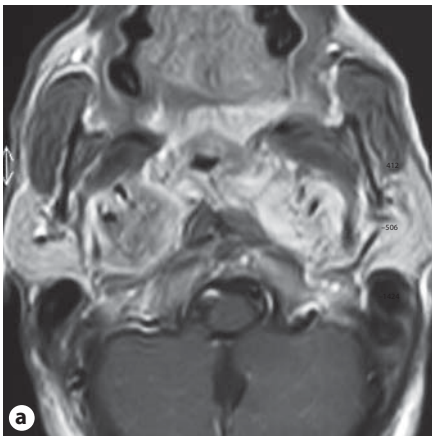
Case No. 9. a Axial T₁-weighted MR image showing bilateral encasement of the ICA by VP. b Selective injection of the left ICA in anteroposterior projection showing stenosis. c Selective injection of ICA after stent deployment, showing absence of stenosis.
